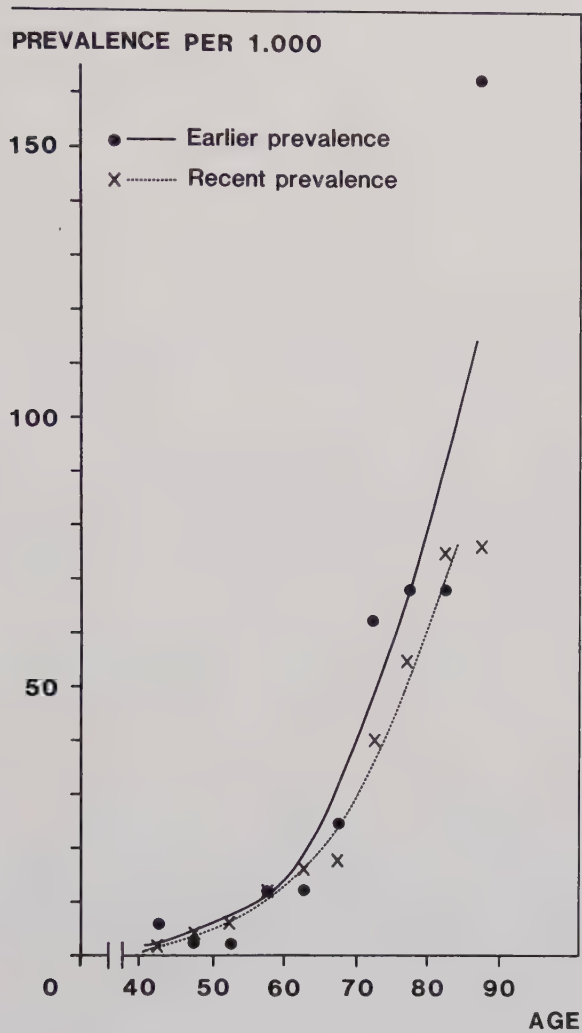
Prevalence of roentgenologic primary coxarthrosis in subjects who have had a colon roentgen examination.
